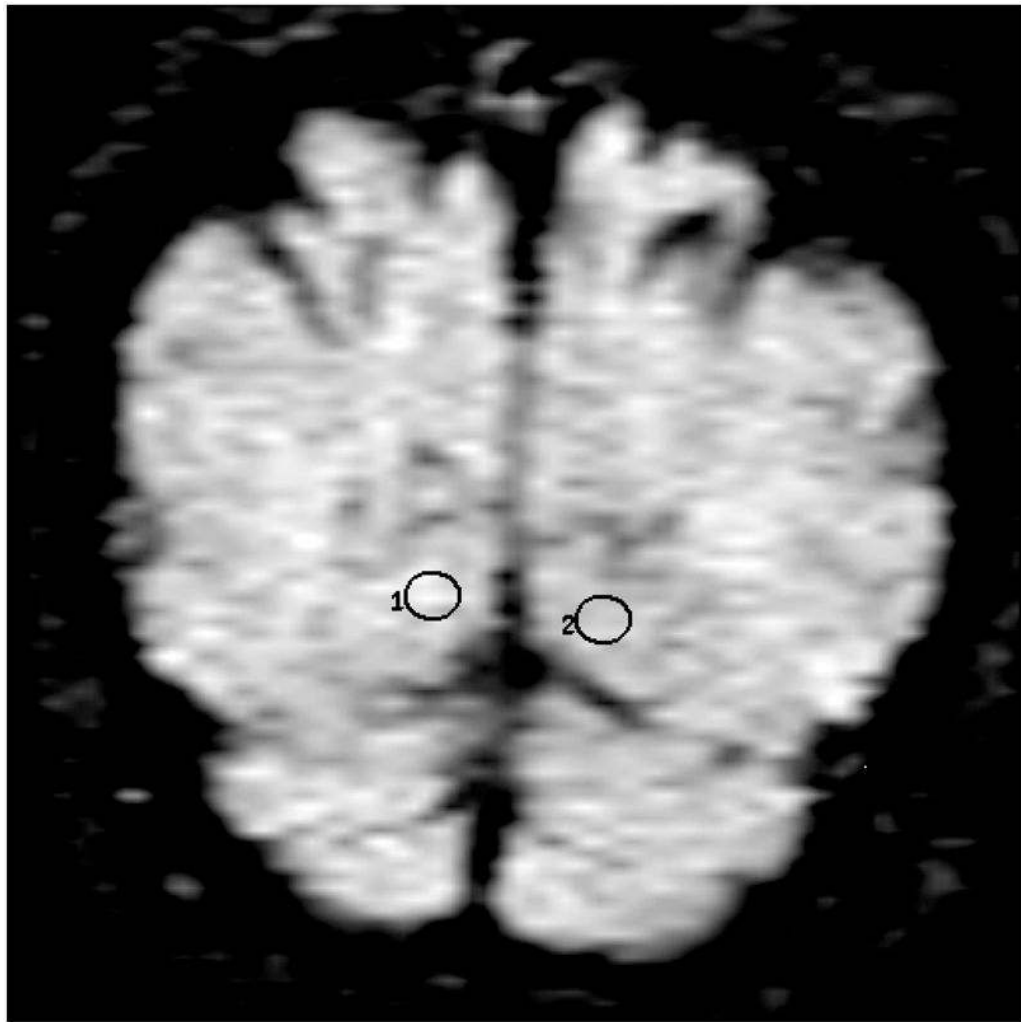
Location of the frontal lobe (a), posterior cingulate (b), parietal (c), and occipital (d) WM ROI on the coronal FLAIR image (9999 /93 /2200, b = 0 s /mm²). (1=right, 2=left)
